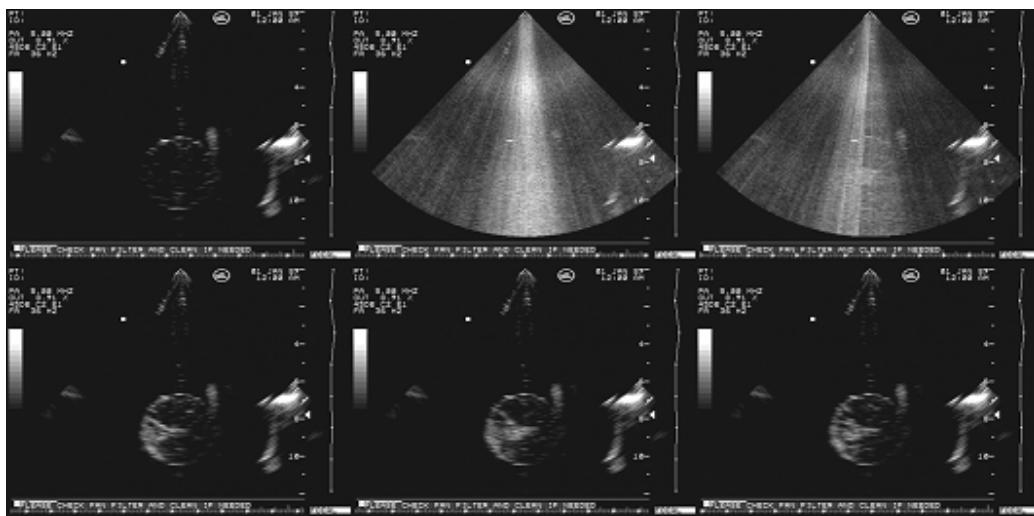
PLA microbubbles excited by an ultrasonic pulse of 1000 mVpp.
